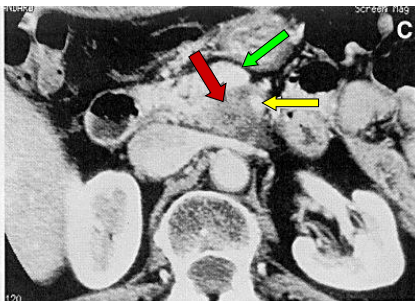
Pancreatic Tumor—Computed tomography demonstrates involvement of the posterior wall of the superior mesenteric vein (green arrow) as well as near-total encasement of the superior mesenteric artery (yellow arrow) by tumor (red arrow). Image courtesy of Giles Boland, MD.
